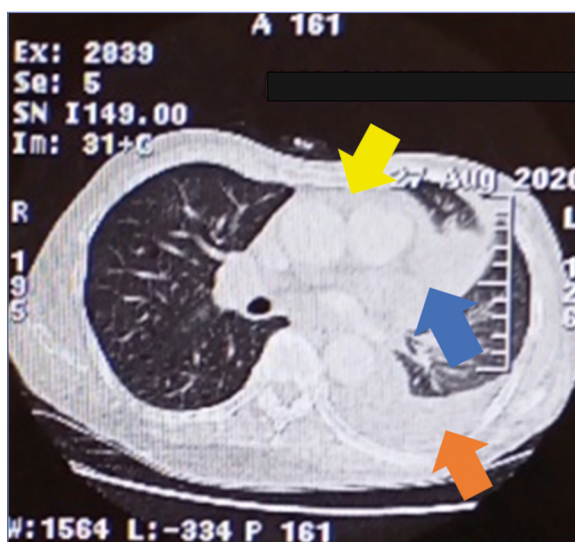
Thoracic multislice computed tomography (MSCT) with contrast at admission. The blue arrow indicates a left lung mass in the left upper lobe, the brown arrow indicates left pleural effusion, and the yellow arrow indicates pericardial effusion
